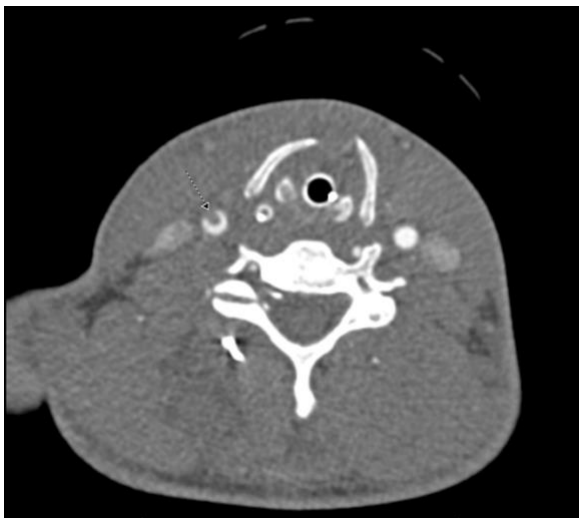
Axial CTA demonstrating a crescent-shaped filling defect in the right common carotid artery.
